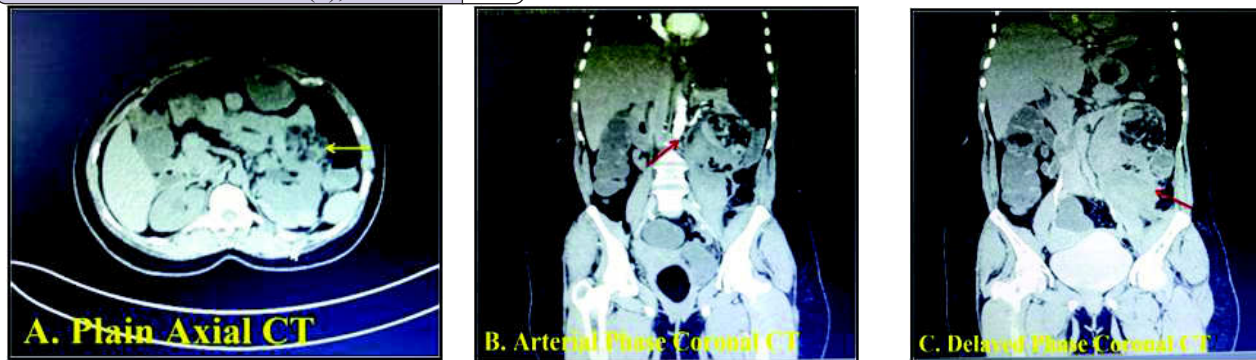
CT scan (A) showing fat density lesion in lower pole of left kidney. (B) showing branches arising from left renal artery supplying the lesion. (C) Intra-lesion & retro-peritoneal hematoma along left psoas
